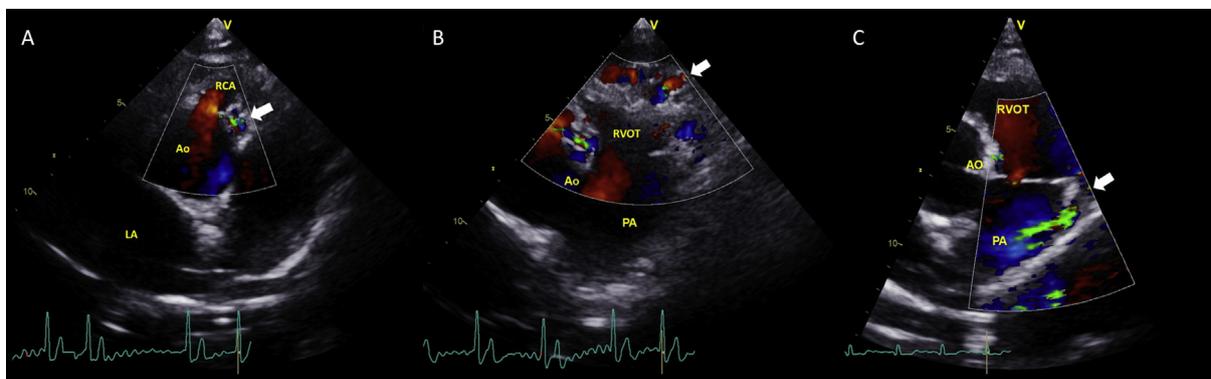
Color-flow Doppler images from a right parasternal short-axis view showing A) turbulent flow within an aberrant vessel between the aorta and pulmonary artery, B) a nest of tortuous vessels adjacent to the right ventricular outflow tract, and C) a jet of antegrade flow entering the pulmonary artery distal to the pulmonic valve. Abbreviations: Ao, aorta; LA, left atrium; RCA, right coronary artery; PA, pulmonary artery; RVOT, right ventricular outflow tract.
